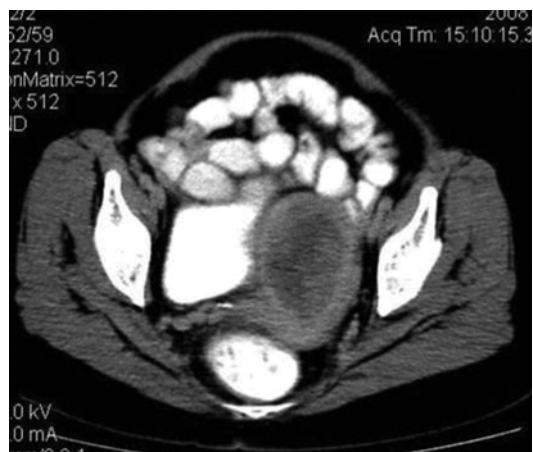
Contrast-enhanced axial CT sections showing heterogeneous hypodense uterine mass (proven carcinosarcoma)
